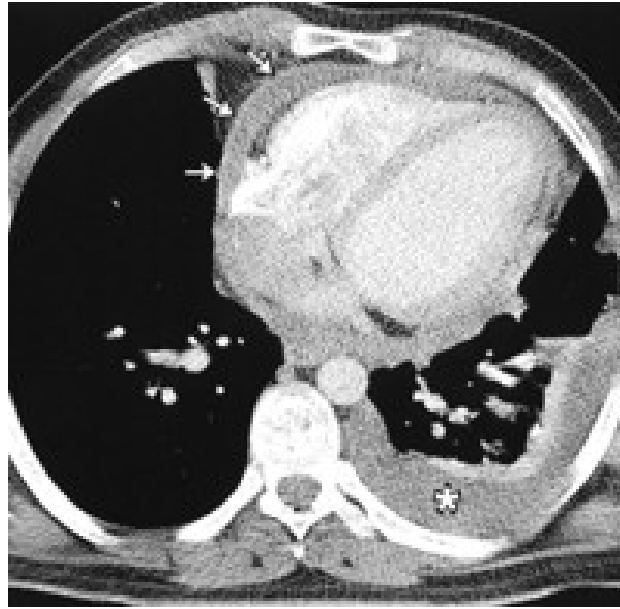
Chest CT from a patient with pericardial constriction showing thickened pericardium (arrows) and a left pleural effusion
